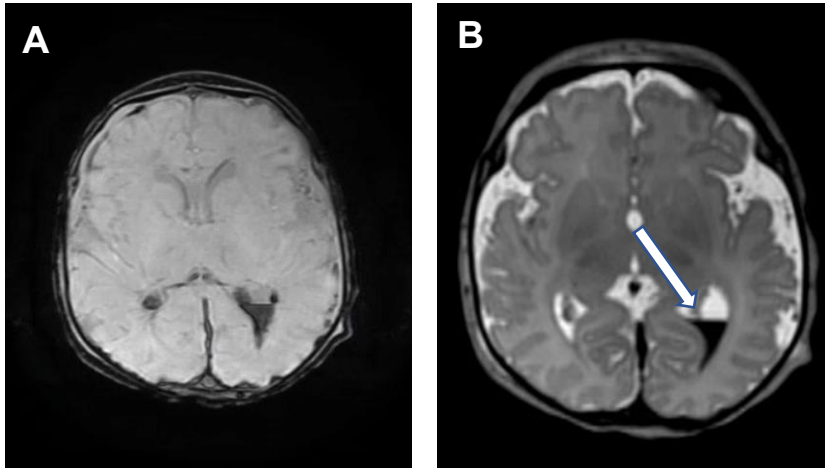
Example of an intraventricular hemorrhage on axial SWAN sequence (A) and axial T2-weighted image (B)
